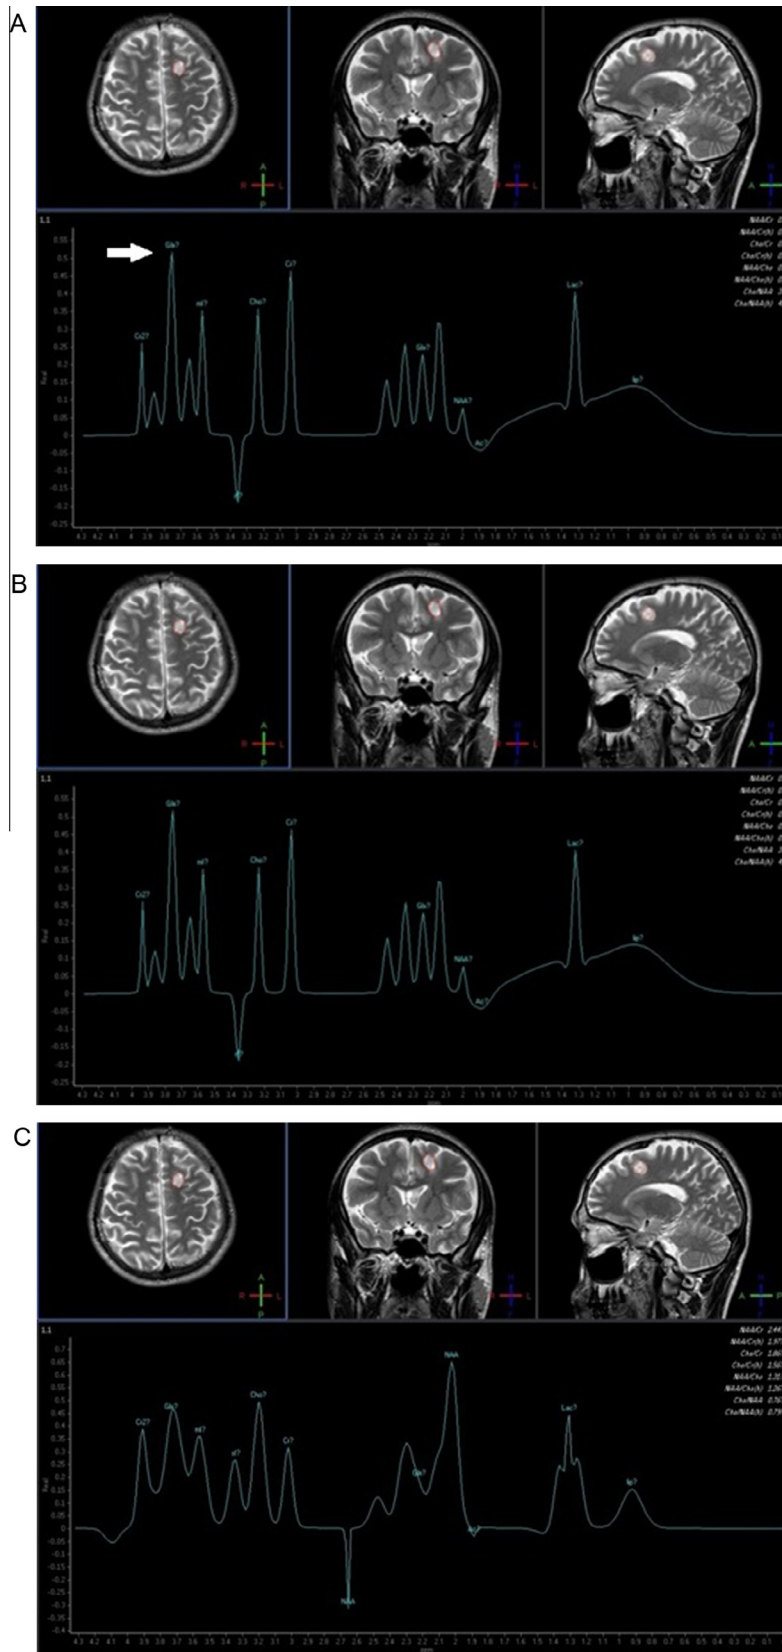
Male patient 17 years old with brain TB (A, B & C) MRI axial T2 weighted image of the brain and MRS revealed: left frontal subcortical intraaxial focus of altered signal intensity: MRS at long and short TR revealed. Well observed Glx peak (white arrow) (Fig. 1A). Cho/Cr: 1.76, NAA/Cr: 0.98, MI/NAA: 0.567.
